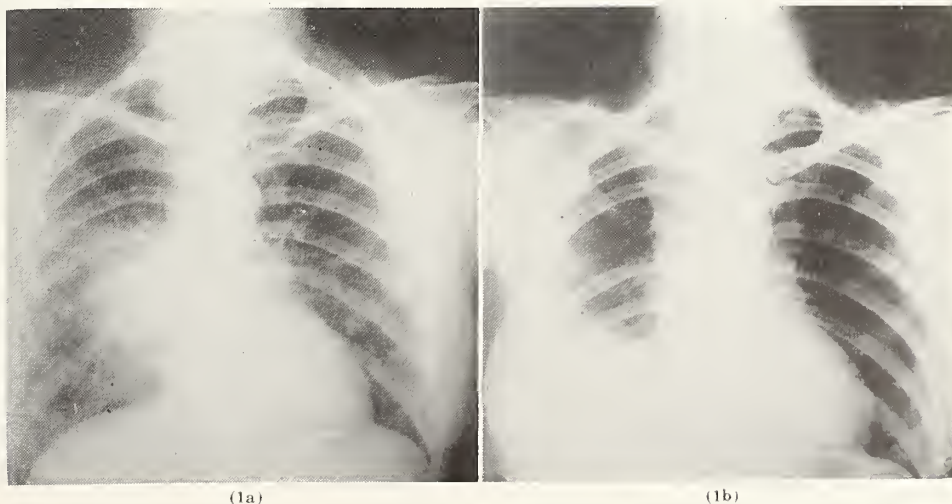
(Case No. 1) (a). X-ray of chest showing infiltration of upper part of right lower lobe. When lesion remained in spite of adequate medical care, exploration was advised since differentiation from primary lung carcinoma was impossible. (b). X-ray appearance of chest following lobectomy.
